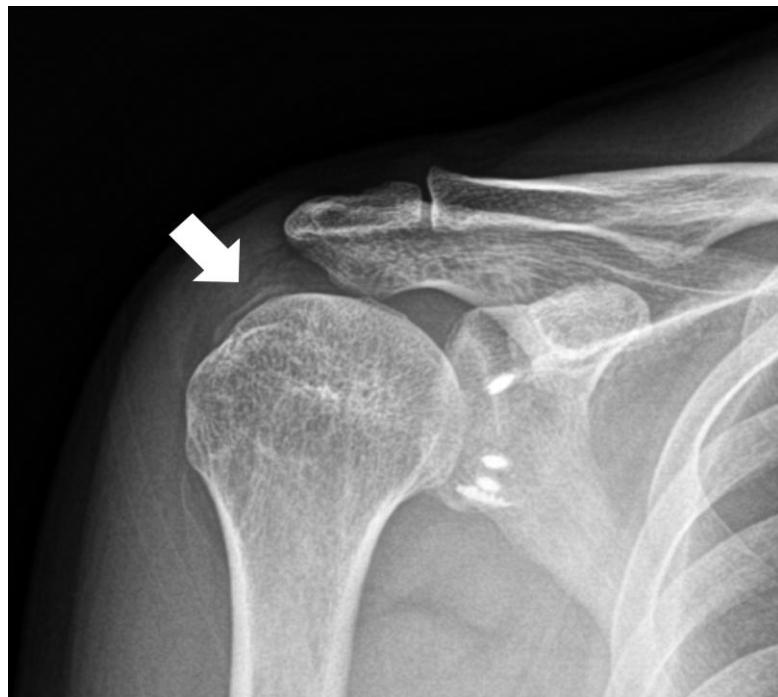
Preoperative anteroposterior radiographs of the right shoulder show multiple metallic anchors in the glenoid (from prior Bankart repair) and a radiopaque lesion over the supraspinatus region.
